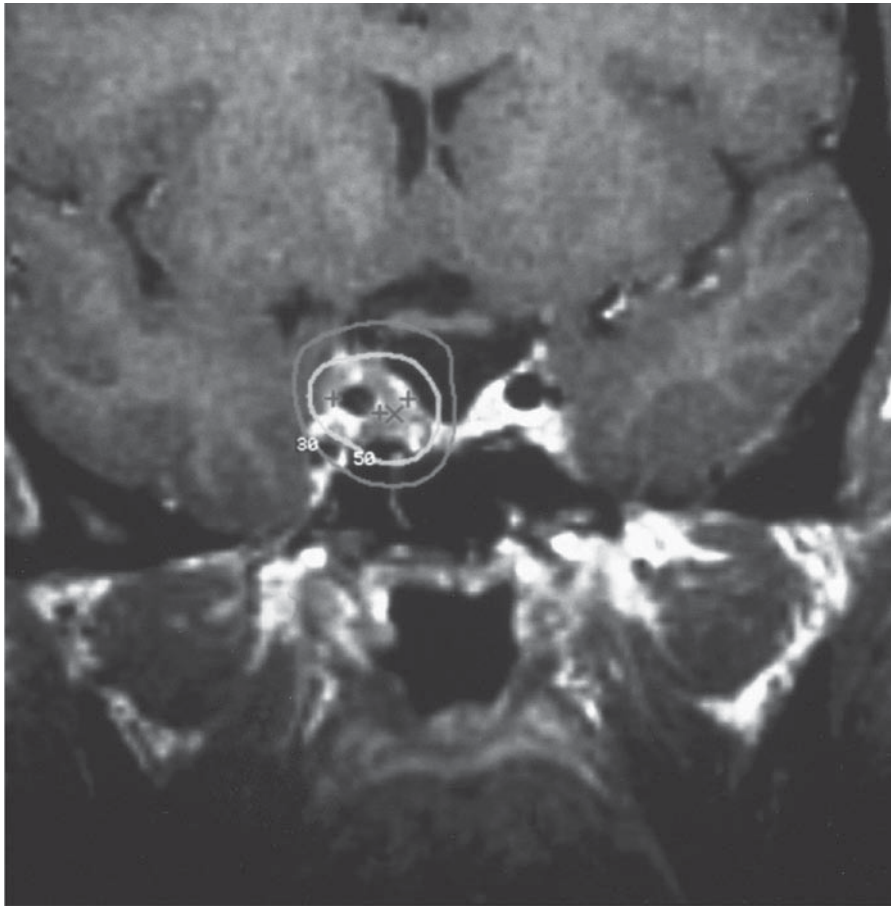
Coronal MRI obtained for computerized treatment planning for a recurrent pituitary adenoma involving the right cavernous sinus. A dose of 15 Gy was administered to the 50% isodose line (yellow). The maximum dose to the tumor was 30 Gy. The dose to the optic chiasm was less than 10 Gy (30% isodose line, green)
